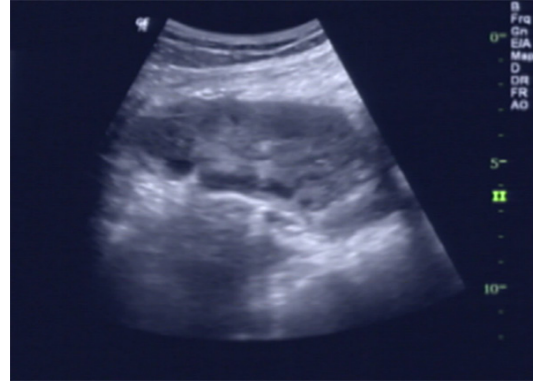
Right ovary in the ultrasoundgram on 7th June 2014.
